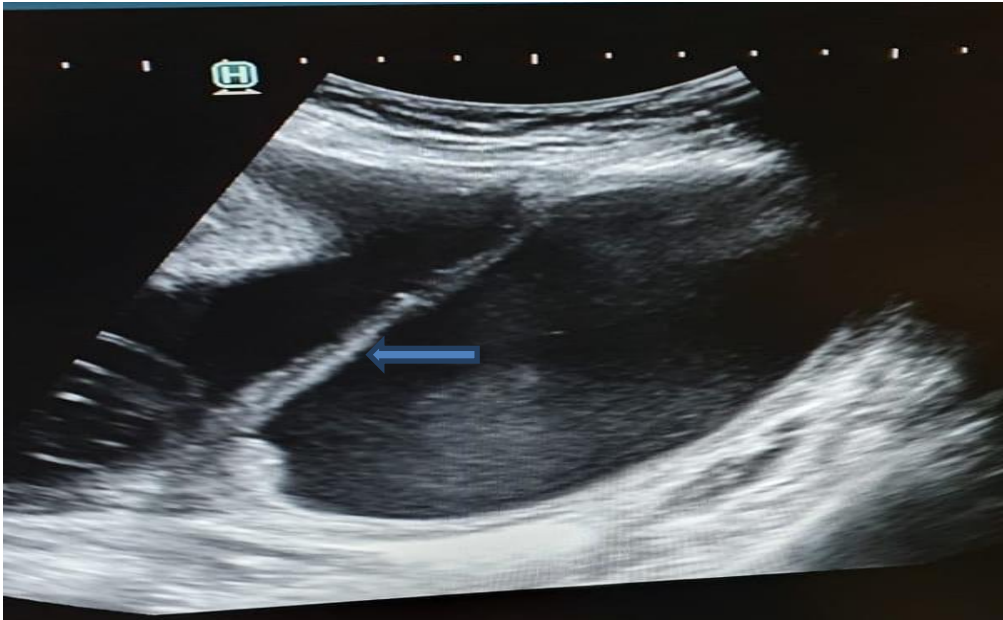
The ultrasonography report revealed amniotic band with thick intrauterine septum
